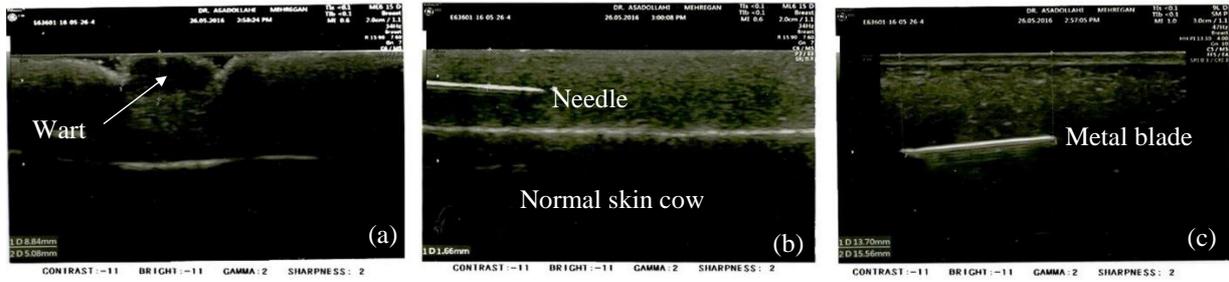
Display of subcutaneous defects in the ultrasonic images: (a) Wart display, (b) Needle display and (c) Metal blade display
